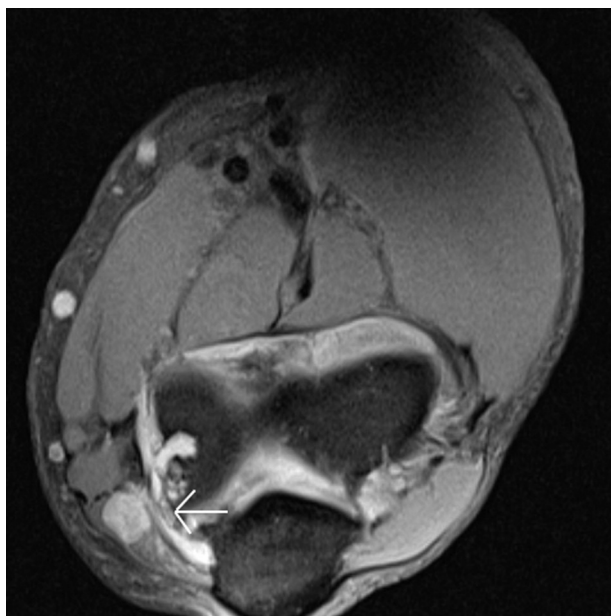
Axial view of a magnetic resonance arthrogram T2-weighted image demonstrating a mass pushing out on and effacing the ulnar nerve. The white arrow depicts the ulnar nerve at the site of compression by the lesion.
